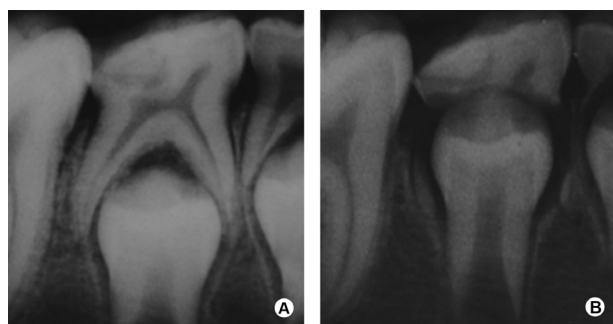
Radiograph of carious lesion in the primary mandibular right second molar (NSBS) at baseline (A) and 12-month follow-up period (B). A decrease of area of caries was observed at final evaluation.
